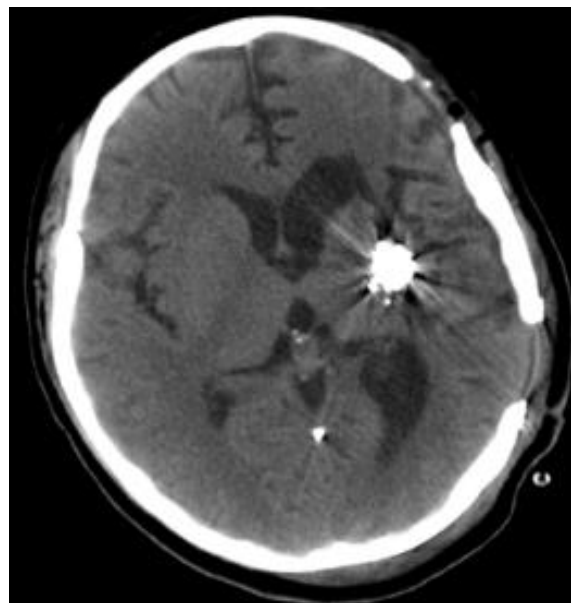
Brain CT after cranioplasty
